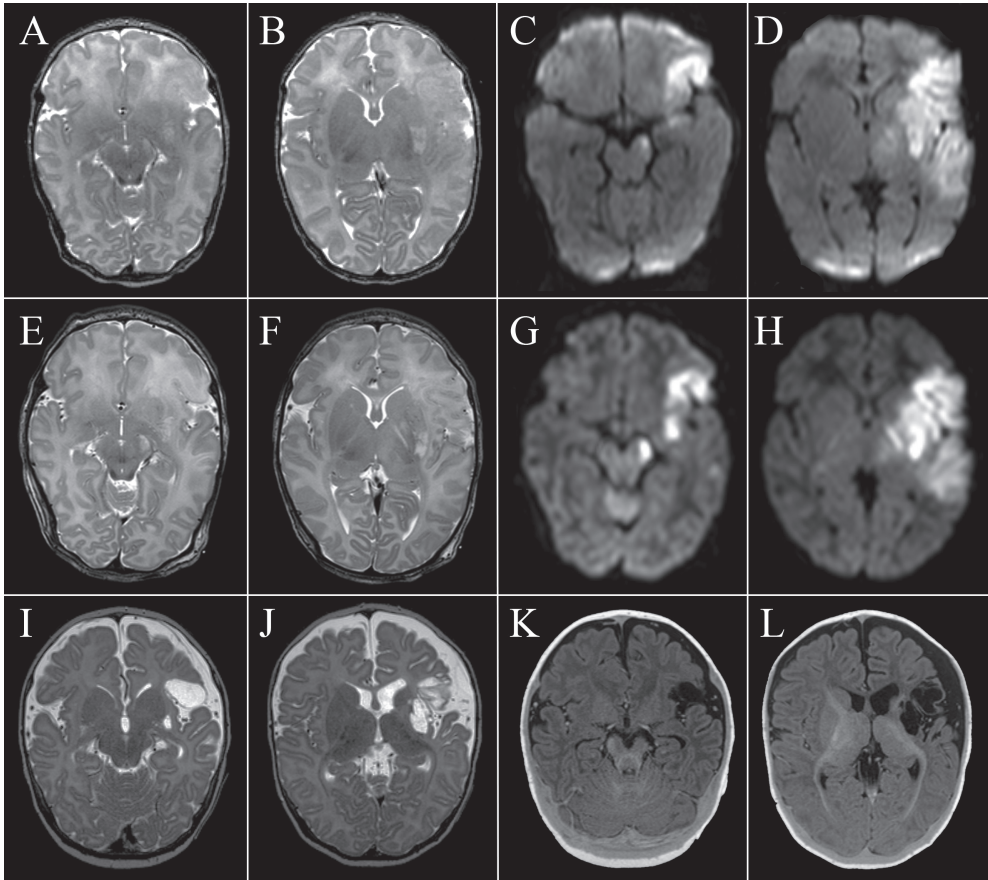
MRI of Case 1. MRI of a newborn (case 1) with a left sided MCA PAIS who had three MRIs: the first within 24 hours (upper row), the second at 72 hours after onset of symptoms (middle row) and the last at three months of age (bottom row). At 72 hours there was an increase in signal intensity in the right cerebral peduncle (A versus E) and PLIC (B versus F) on axial T2 weighted imaging compared to the first scan. On early axial DW imaging mild lateral signal changes can be observed in the cerebral peduncle (C), while a profound hyperintense signal was seen at 72 hours after onset of seizures (G). Signal changes in the PLIC on DW imaging were very clear after 72 hours (H), but not on the first MRI (D). Repeat MRI (bottom row) at the age of three months showed cysts in the left hemisphere, especially in the region of the anterior branch of the MCA (I-J). On Inversion Recovery T1 weighted imaging (axial view) Wallerian degeneration of the left descending CST, involving the cerebral peduncle (K) and PLIC (L) is noted.
